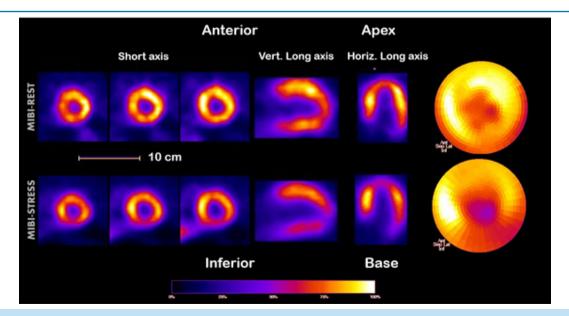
Representative slices of stress-rest SPECT imaging with 99mTc-sestamibi of a 66-year-old female patient with CCC and normal coronary arteries on angiography, presenting reversible perfusion defects in the segments of the apex and inferior wall, involving 22% of the LV polar map surface area (stress).
